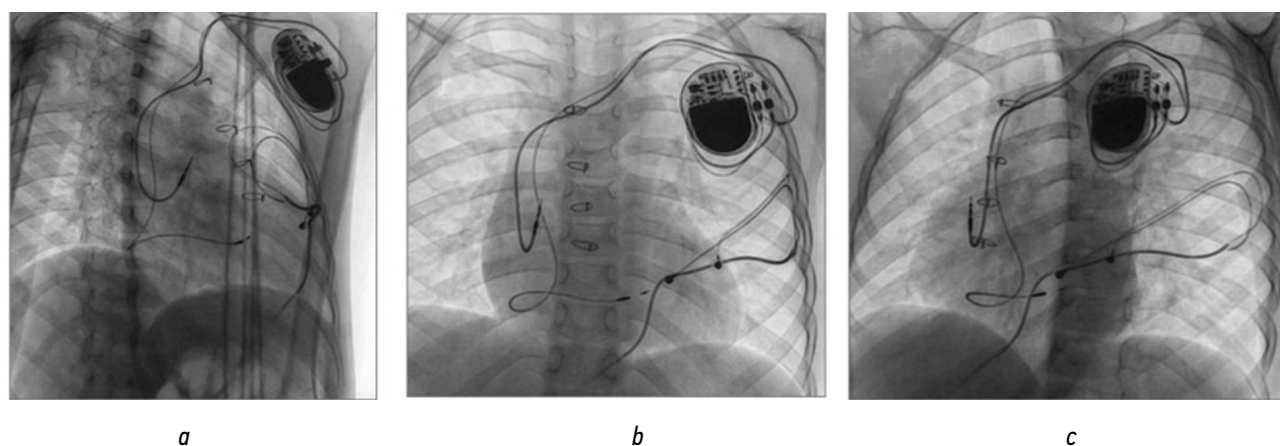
Chest radiography after implantation of an endocardial dual-chamber pacemaker system with a ventricular lead in the left bundle branch: (a) right oblique view; (b) anteroposterior view; (c) left oblique view. © Dishekov et al., 2024.
